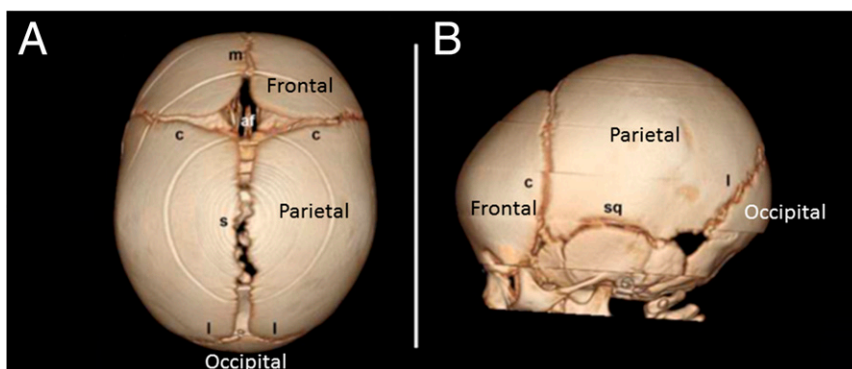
Three-dimensional CT scan showing (A) top and (B) side views of the skull bones with metopic (m), sagittal (s), coronal (c), lambdoid (l), and squamosal (sq) sutures, as well as the anterior fontanelle (af). Reproduced with permission from Governale LS. Craniosynostosis. *Pediatr Neurol.* 2015;53(5):394-401.
